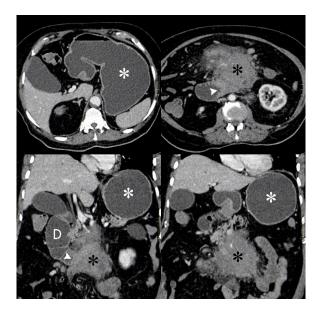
Axial (top row) and coronal (bottom row) CT images from an initial diagnostic portal venous phase contrast enhanced CT when patient presented with symptoms of gastric outlet obstruction. Fluid filled dilated stomach (white asterisk) and 2nd and 3rd part of duodenum. Ill-defined enhancing mass in the root of the mesentery (black asterisk) obstructing the 3rd part of the duodenum (white arrowhead).
